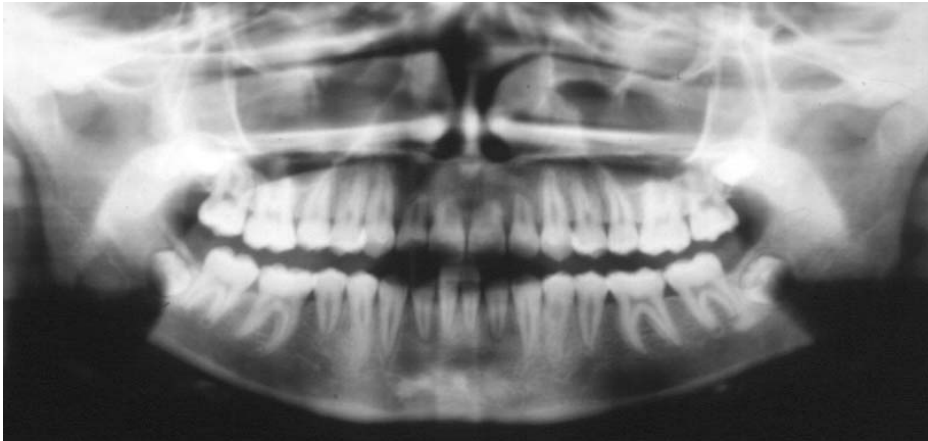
Final panoramic radiograph.
